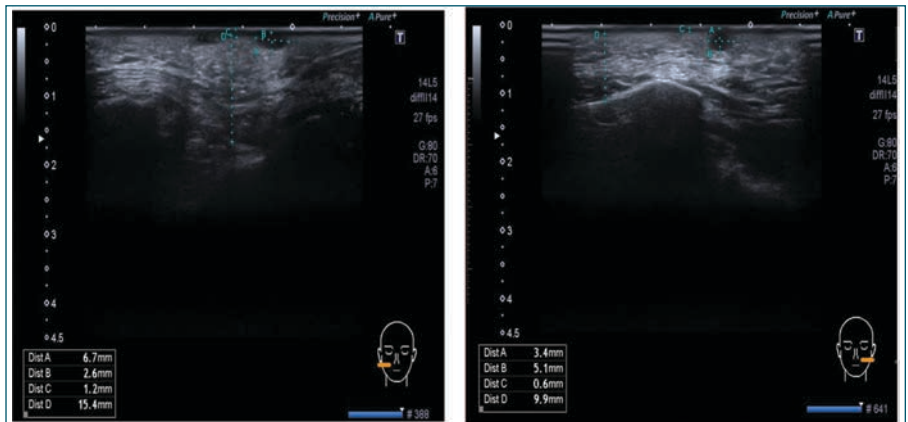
Baseline sonographic measurements of the right and left malar region (Ax: x, y-axis dimensions of the largest scar in the area; C: dermis thickness, D: subcutaneous tissue thickness).
